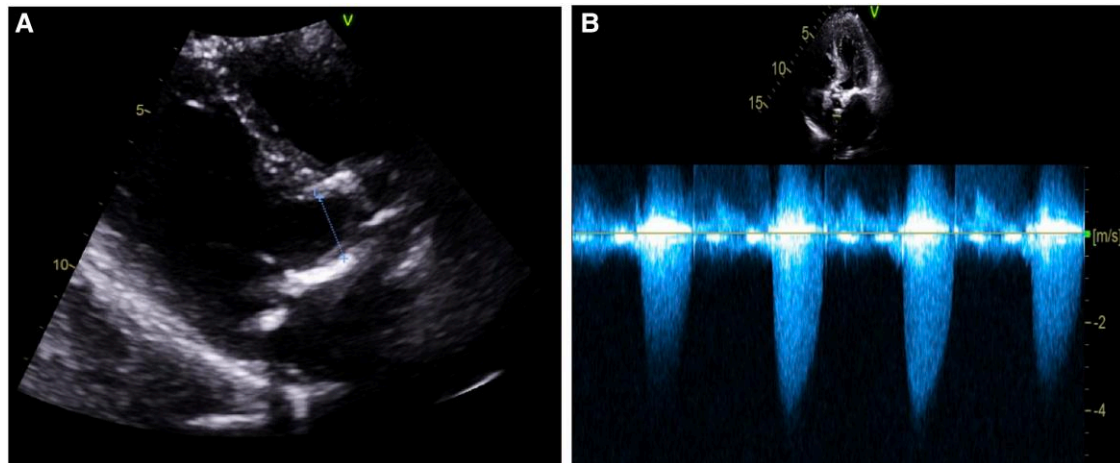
Representative echocardiographic images showing the (A) aortic valve diameter and (B) velocity through the aortic valve.
